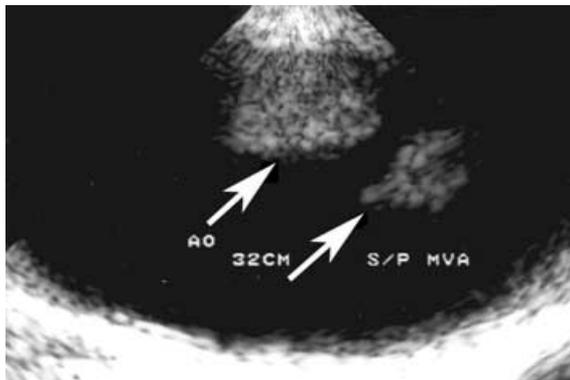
TEE image of a 24-year-old unrestrained driver who bent the steering wheel upon impact. An intimal tear was evident, with the medial layer remaining intact. A mobile thrombus (arrows) was noted at the site of the intimal tear. (With permission from Kerut EK, McIlwain EF, Plotnick GD: *Handbook of Echo-Doppler Interpretation*, 2nd Ed, Blackwell-Futura Publishing Co., Elmsford, NY 2004, p. 226.)
